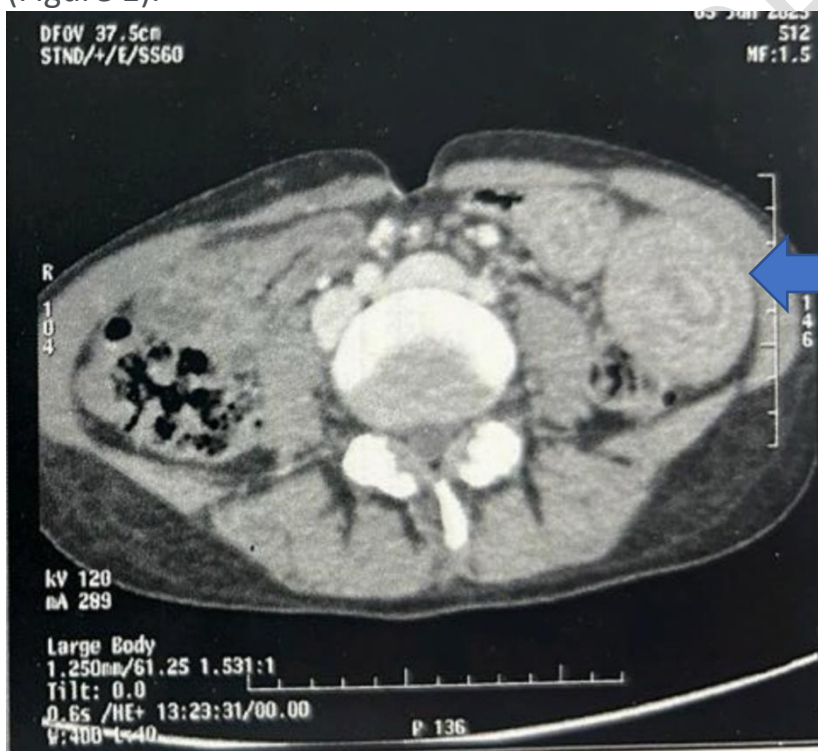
CT scann showing target sign
